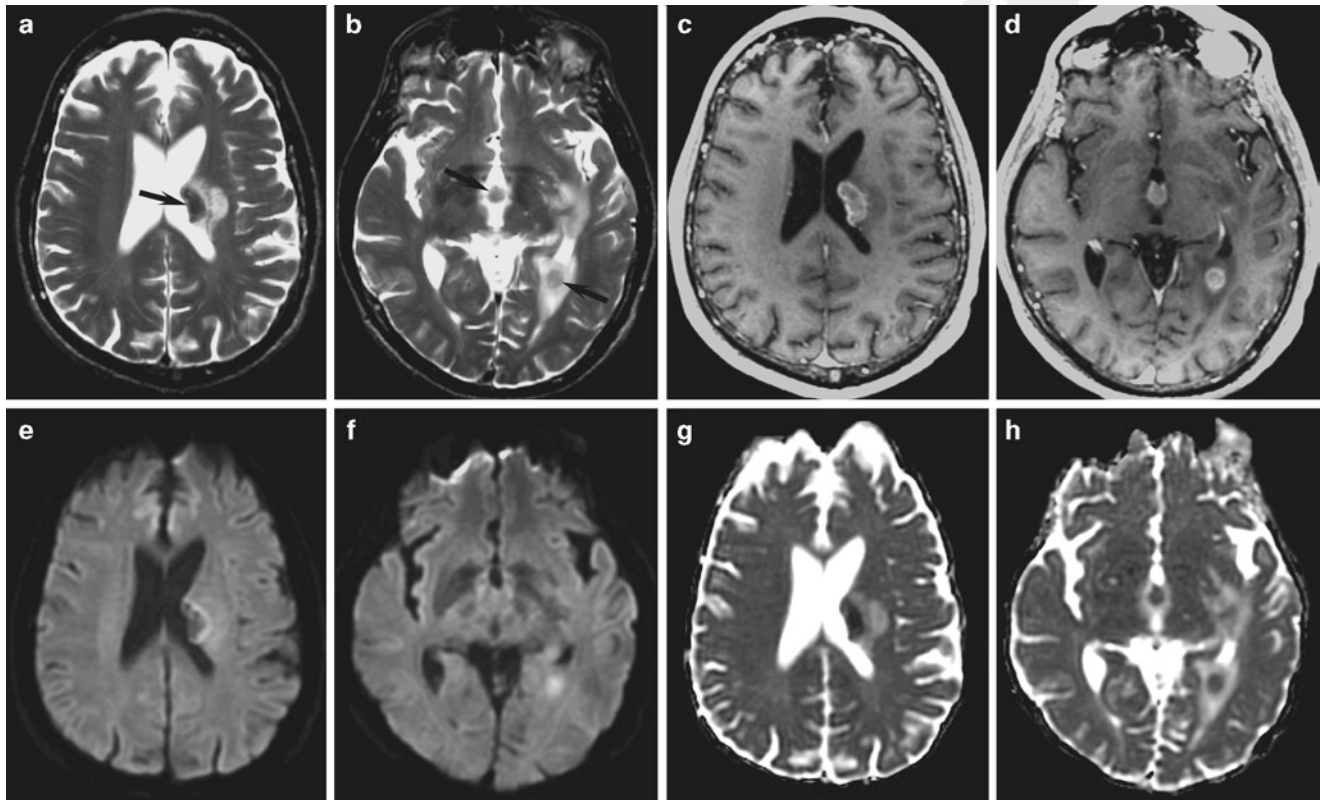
Lymphoma. (a, b) Axial T2 and (c, d) postcontrast T1-weighted images demonstrate multiple subependymal enhancing lesions that have relatively low signal on T2 (arrows in (a) and (b)). (e, f) On DWI, the lesions are heterogenous but partially bright. (g, h) On ADC, the lesions are hypointense consistent with restricted diffusion
